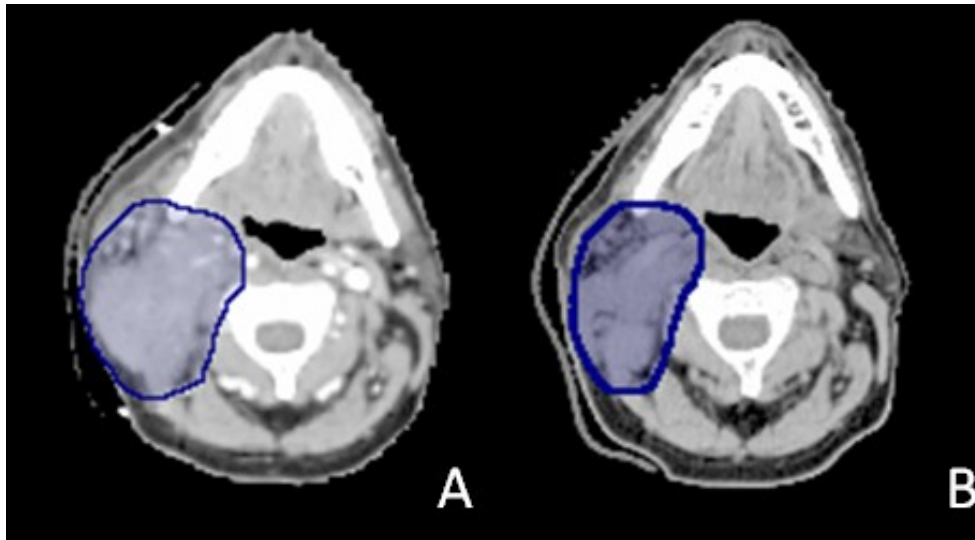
An example of a head and neck cancer patient experiencing tumor shrinkage. (A) CT scan before treatment. (B) Re-CT scan in the fourth week of the treatment course. Blue contours indicate the tumor area.
